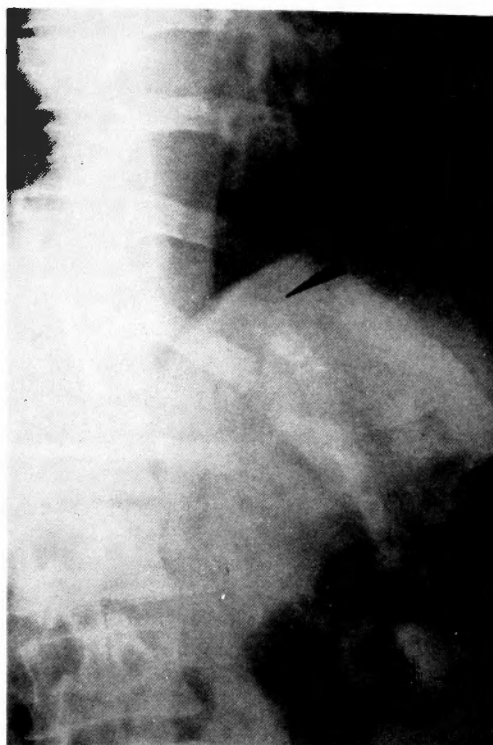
X-ray film of the lumbar vertebra in oblique position showing heterotopic bone formation; arrows indicate the length
